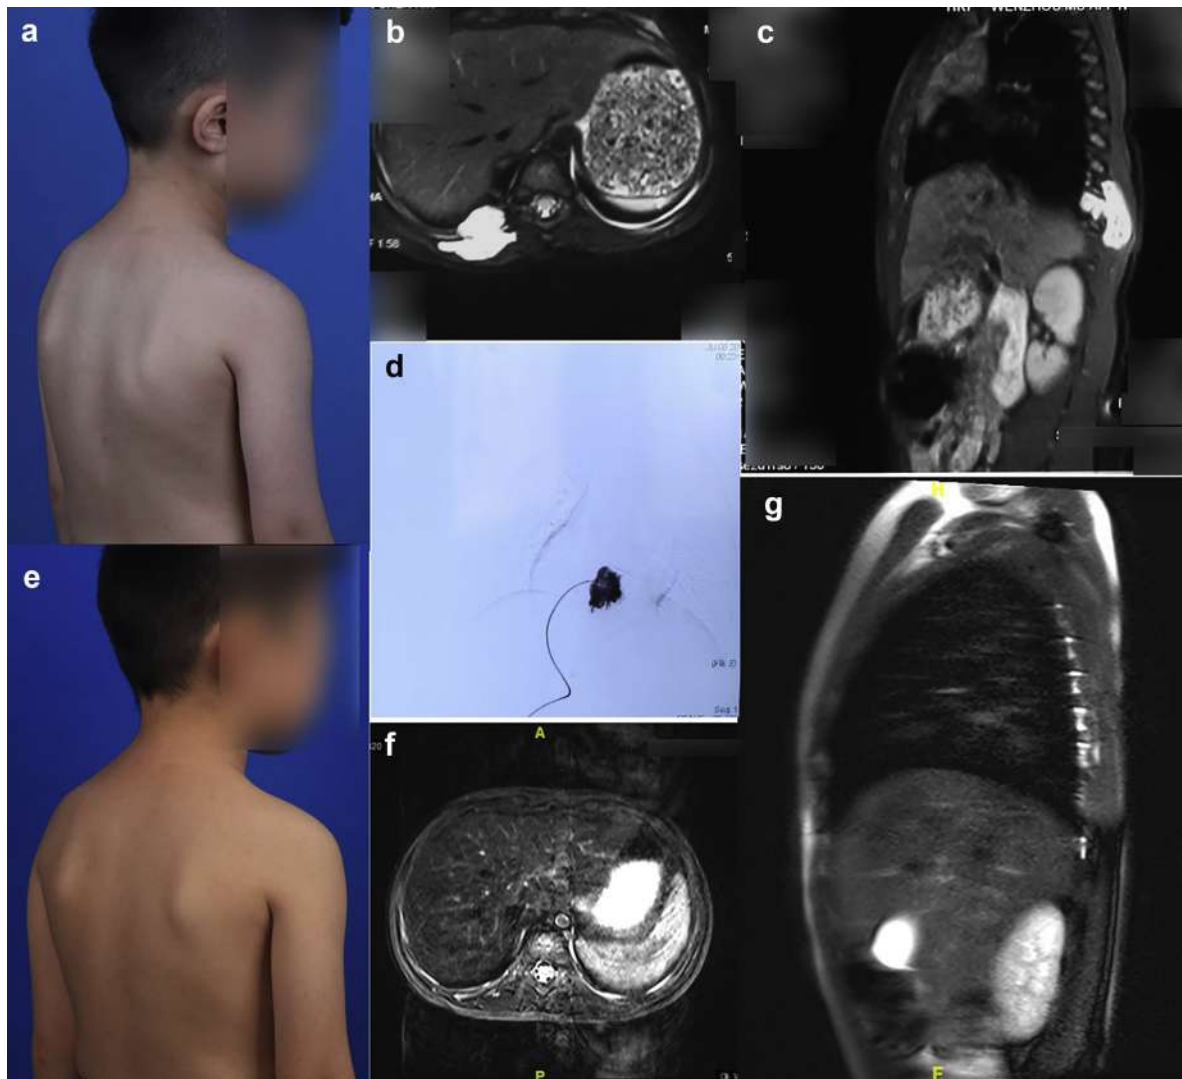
A 4-year-old boy with localized venous malformation (VM) of the back treated by bleomycin-polidocanol foam (BPF) sclerotherapy. a, Clinical appearance before treatment showing a mass on the right side of the back. b and c, Pretreatment T2-weighted magnetic resonance imaging (MRI) showing a hyperintense mass of the right side of the back involving the thoracic cavity. BPF sclerotherapy was performed under digital subtraction angiography. d, Phlebography showed that the lesion was localized, and no outflow vein was observed. e, After one session of BPF sclerotherapy, significant improvement of VM lesions was achieved. f and g, Post-treatment T2-weighted MRI 3 months after treatment showing complete disappearance of VM lesions.
